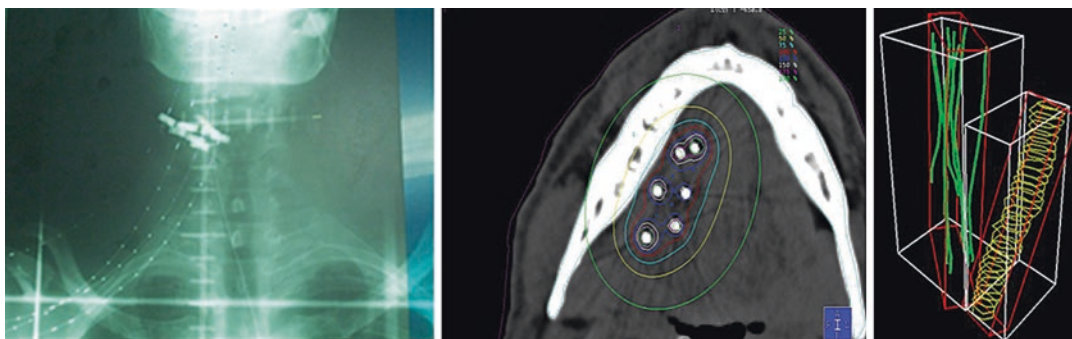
2D X-ray based and CT based planning in patients with head and neck brachytherapy
